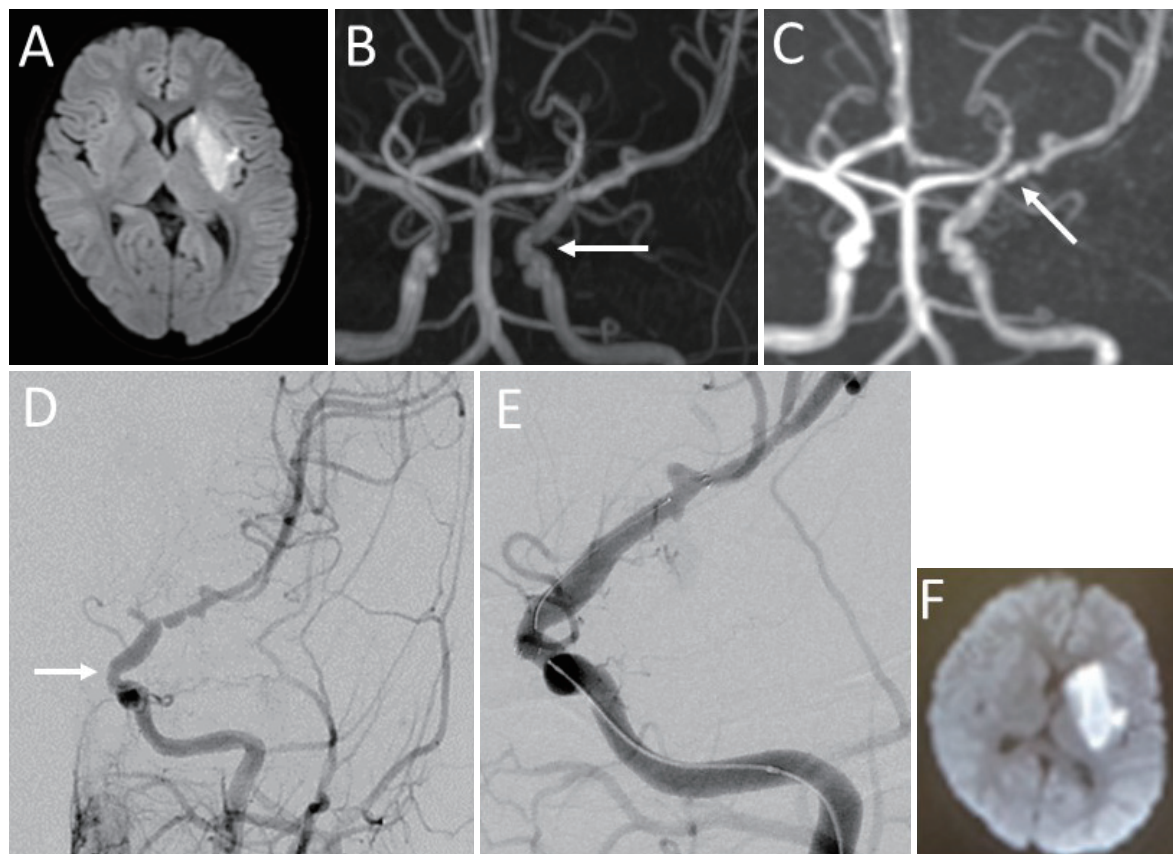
Case 22. An 8-year-old boy presented with pain in the left eye and subsequent right hemiparesis and aphasia. A, B: DWI (A) and MRA (B) at the previous hospital 1 h after the onset showed a hyperintense lesion in the left basal ganglia and wall irregularities starting from the C2 portion of the left supraclinoid ICA (arrow) to the left M1 and A1 portions. C: MRA on the next day showing an aggravation of the stenosis of distal ICA and M1 (arrow). D: An AP view of the left carotid angiogram on the same day showing a pearl and string sign starting at the left C2 portion (arrow) involving M1 and A1. E: The same angiogram as D at the end of stenting using Enterprise2™ showed an improvement in the stenosis. The left A1 was iatrogenically occluded. However, the anterior communicating artery provided a collateral flow. F: DWI on the next day of the intervention demonstrated infarction in the left basal ganglia, which was similar to that shown in A, except for some edema.
